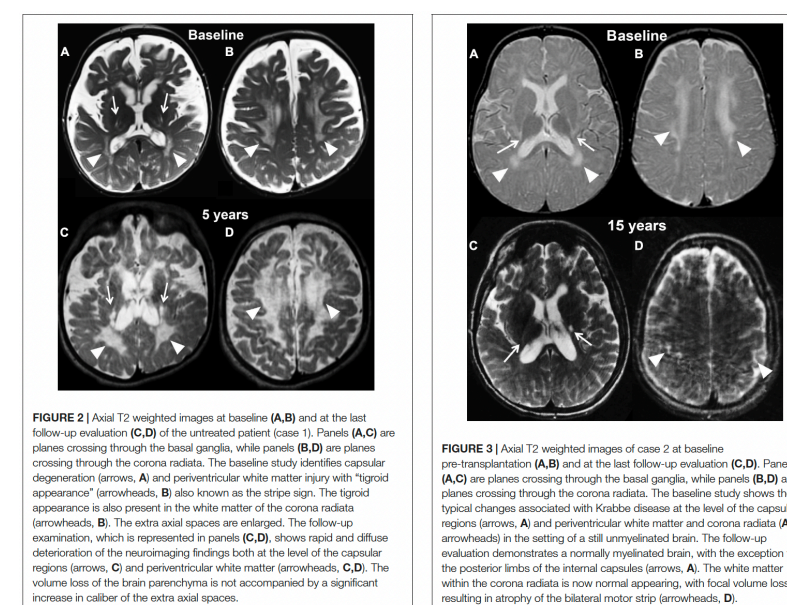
Case 1: Axial T2-weighted images of the brain at baseline (A,B) and at 5 years follow-up (C,D) of the untreated patient (Case 1). Panels (A,C) are slices crossing through the basal ganglia, while panels (B,D) are slices crossing through the corpus callosum. The baseline study shows capsular degeneration (arrows, A) and periventricular white matter injury with "typical appearance" (arrowheads, B) also known as the "stop sign". The typical appearance is also present in the white matter of the corpus callosum (arrowheads, B). The extra axial spaces are enlarged. The follow-up examination, which is represented in panels (C,D), shows rapid and diffuse enlargement of the neuroanatomical findings at the level of the capsular region (arrows, C) and periventricular white matter (arrowheads, C,D). The relative loss of the brain parenchyma is not accompanied by a significant increase in caliber of the extra axial spaces.
